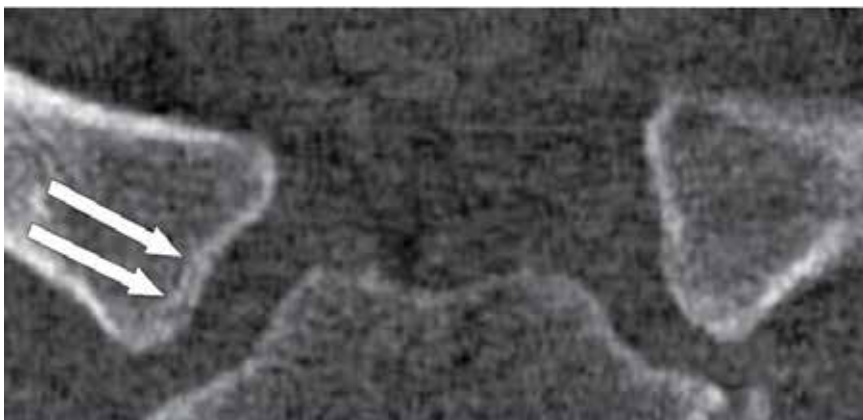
Case 2: CT scan of the sterno-clavicular joints, the arrows show remnants of the epiphyseal scar of the right clavicle
